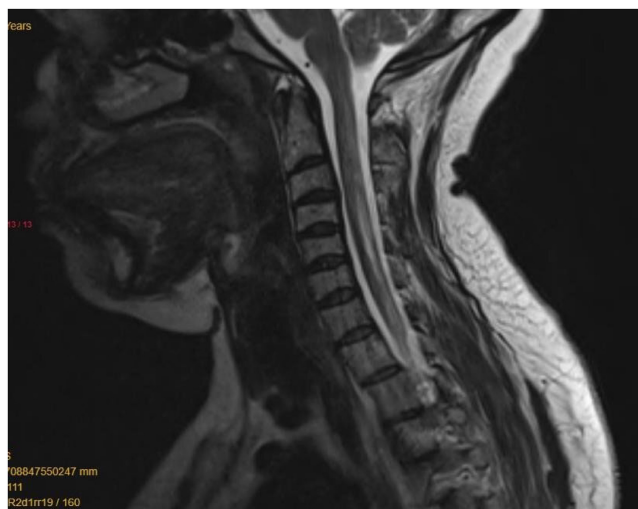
(Sagittal T2): The cervical cord demonstrates a longitudinally extensive spinal cord lesion, with hyper-intense signals in T2 and FLAIR images. The central cord is involved. No hemorrhage.
